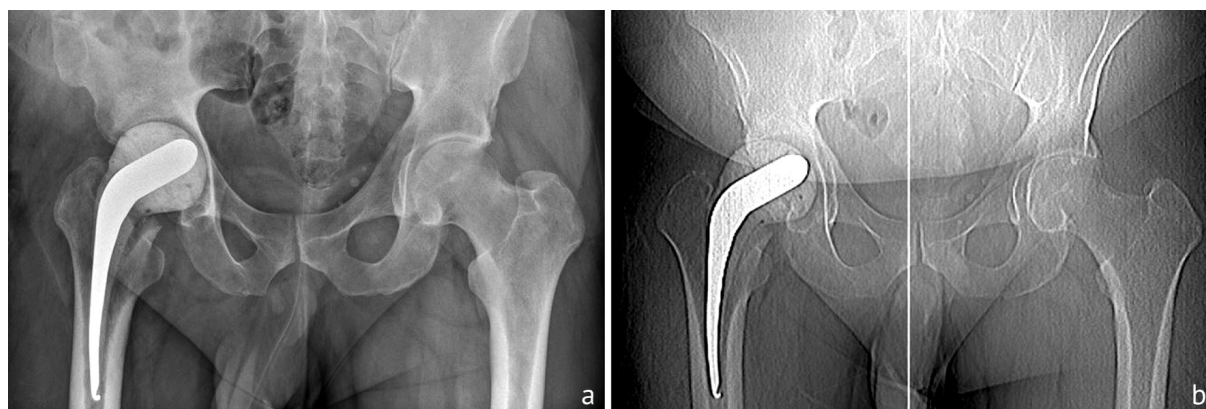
Radiographs of the patient's right hip joint: (a) the first day after surgery with the articulating cement spacer placed; (b) at three months of surgery
